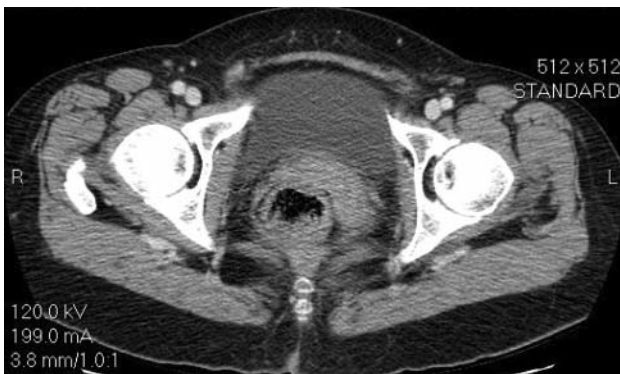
Abdominal CT scan detecting thickening of the left levator ani muscle.
